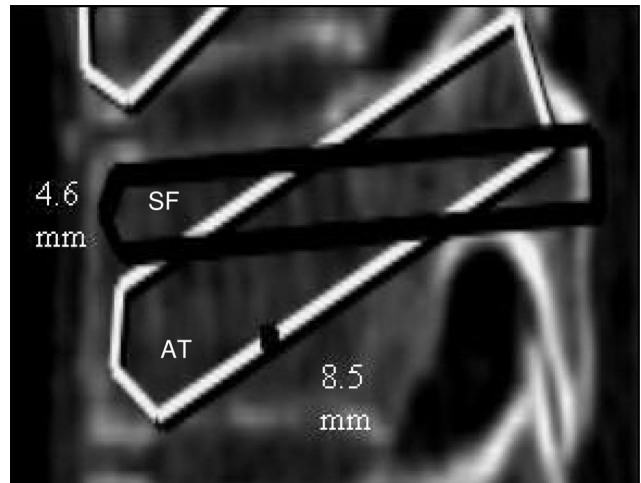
EPD as seen on a sagittal CT slice for the anatomic trajectory (white) and for the straight forward/straight ahead trajectory (gray).
